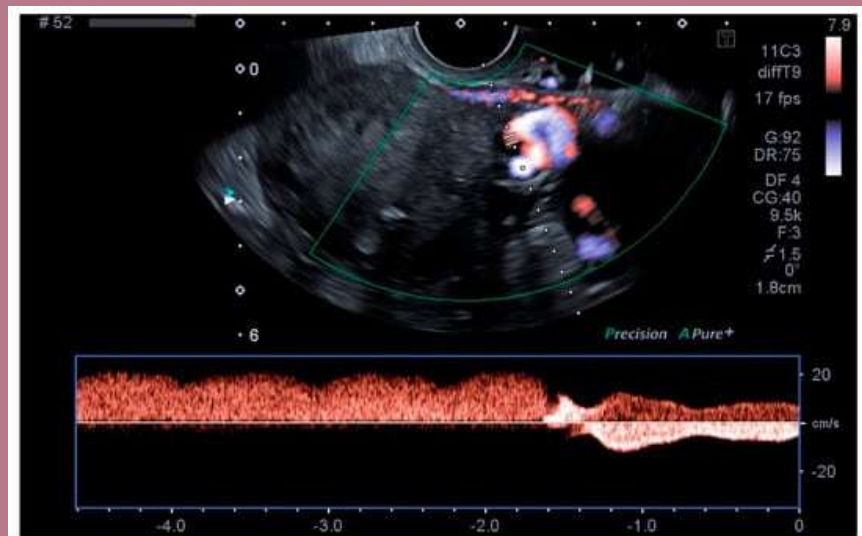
Transvaginal ultrasound imaging of the uterine venous plexus with Spectral Doppler tracing demonstrating reflux with Valsalva maneuver.<sup>24</sup>
